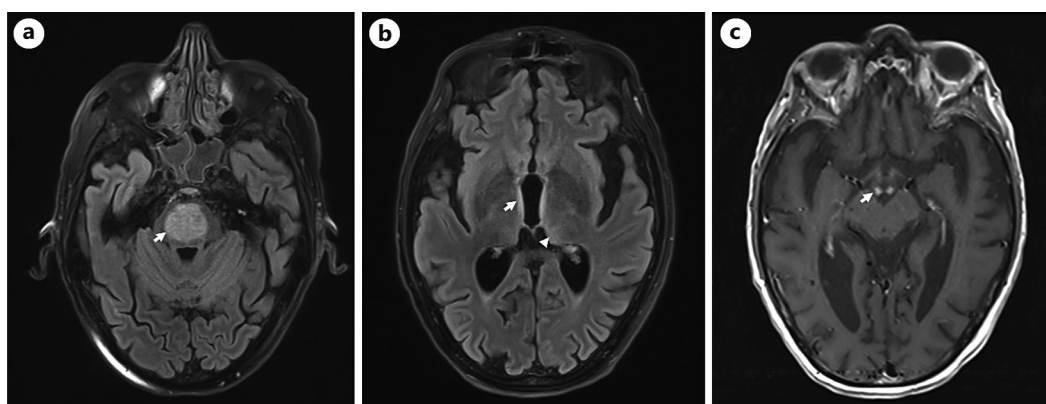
MRI demonstrating: a FLAIR/T2 hyperintense lesion in the central pons (arrow), consistent with central pontine myelinolysis (a); FLAIR/T2 hyperintensity in the wall of the third ventricle (arrow) and dorsomedial thalami (arrowhead) (b); and post-contrast enhancement of the mammillary bodies on the T1-weighted sequence (arrow) (c). The findings in (b) and (c) together are consistent with Wernicke encephalopathy.
